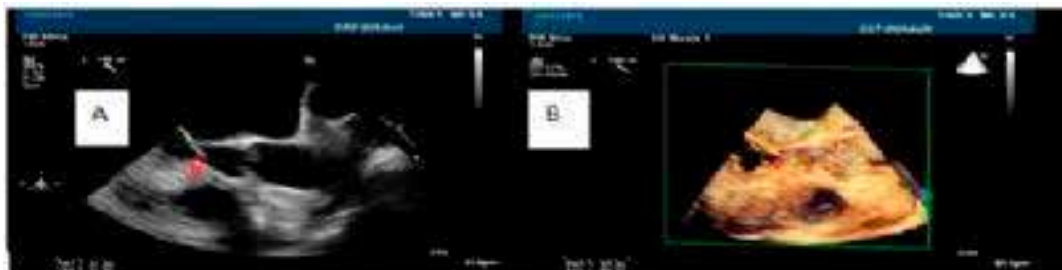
Discrete subaortic membrane in transesophageal echocardiography (TEE). Figure 2B: Discrete subaortic membrane in 3D TEE
